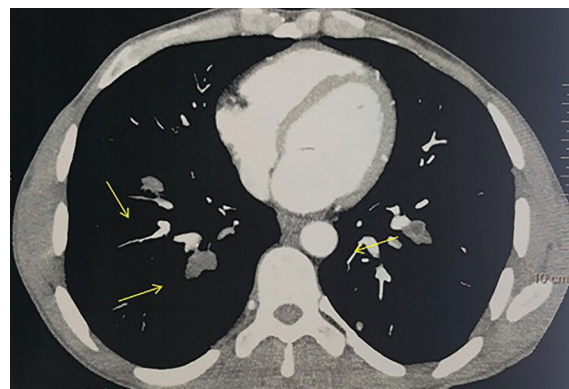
Axial CT section performed after intravenous injection of a contrast agent shows more enhancement defects (arrows) of the segmental and sub-sections segmental pulmonary arteries filled with the material corresponding to hydatid embolism.
